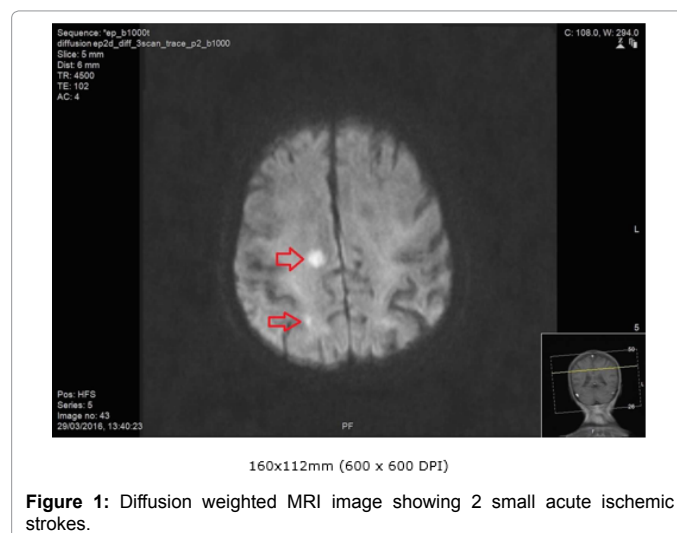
Diffusion weighted MRI image showing 2 small acute ischemic strokes.
